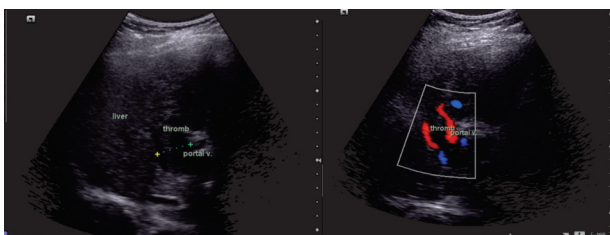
Ultrasound and color Doppler findings in patient with portal vein thrombosis. Enlarged portal vein fulfilled with echogenic material on gray-scale; Color Doppler demonstrated the presence of flow in periportal collaterals*
